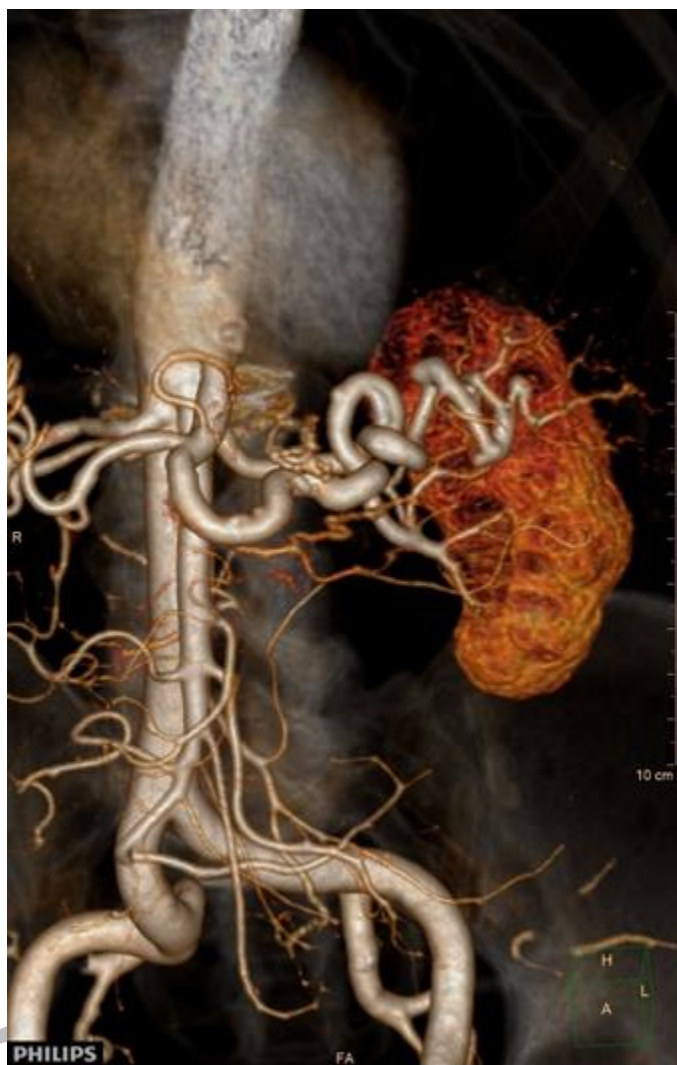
Multidetector computed tomography angiography; splenic artery after the reconstruction
